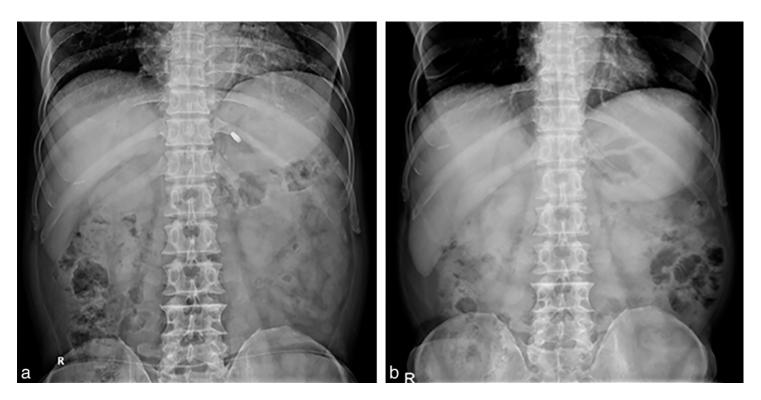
An immediate postoperative radiograph revealed a 1.36 3 0.6 cm well-defined foreign object in the left upper quadrant (a). However, no foreign body was detected in an abdominal X-ray that was taken 1 year later (b).
